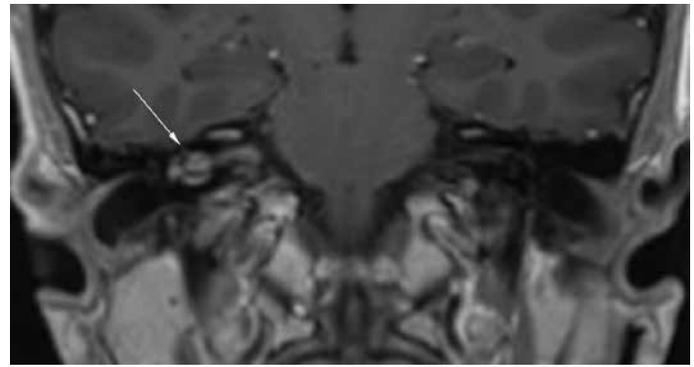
Axial, coronal, and coronal MIP images obtained with T1-weighted sequences with a paramagnetic contrast medium show high signal in the right labyrinth, i.e., the site of schwannoma (white arrow), with an extension in IAC (arrowhead). There is no evidence of signal in the right middle ear. On the contralateral side, there is no signal enhancement in any ear structure.
